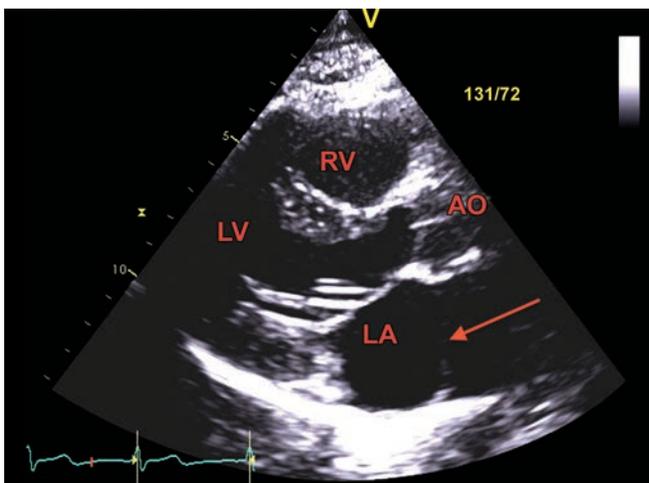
Parasternal long-axis view demonstrating a membrane in the left atrium (arrow).
